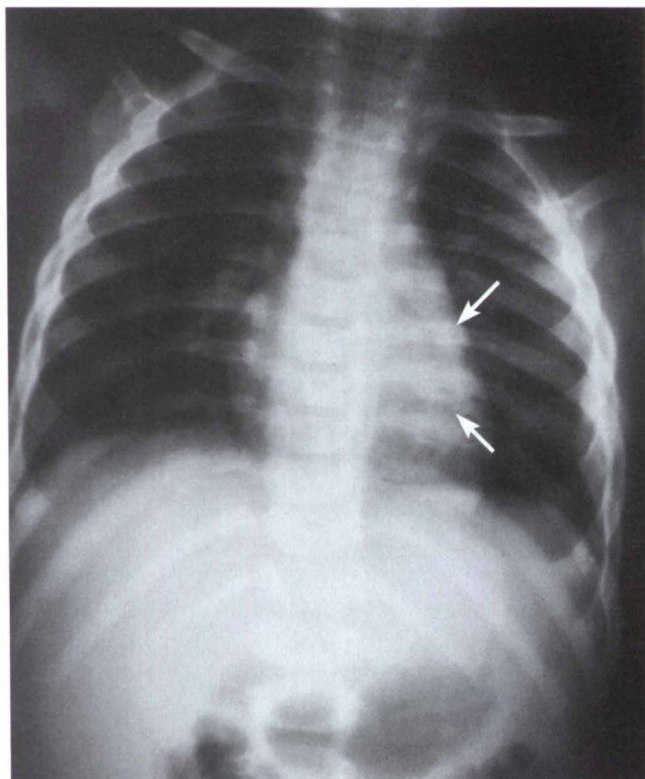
Chest radiograph showing different stages of healing posterior rib fractures (arrows).
